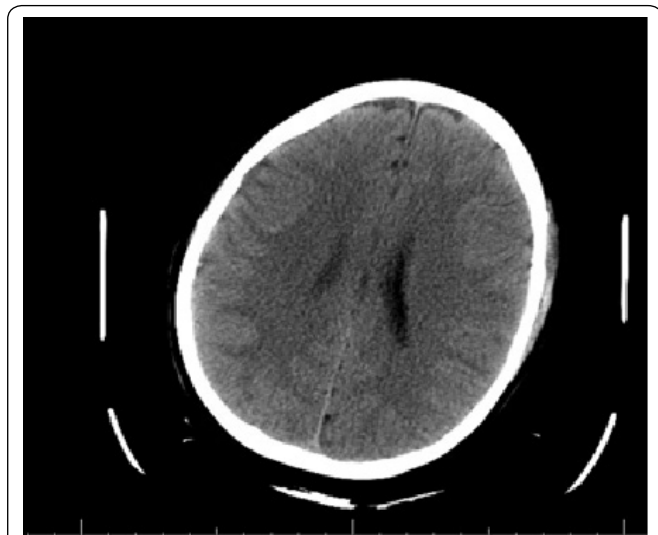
CT brain: focal cortical thickening in right posterior parietal lobe
